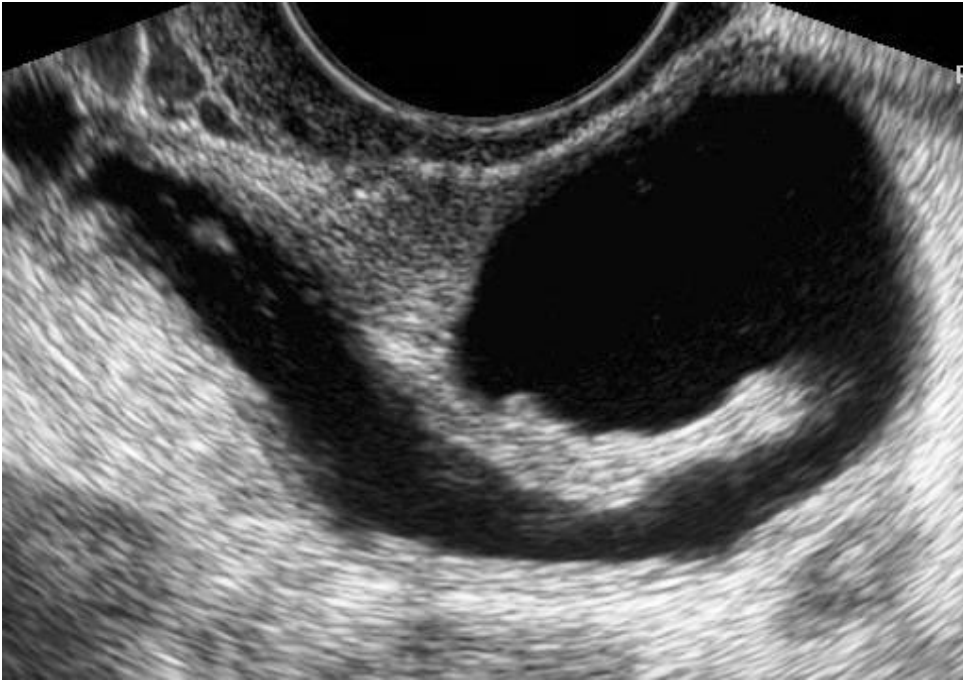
Shows Transvaginal ultrasound image of Hydrosalpinx of 32 years
